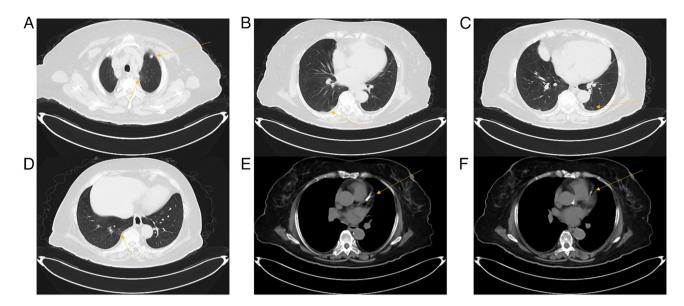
Chest CT demonstrating (A) a large nodular shadow in the upper lobe of the left lung, (B-D) an increased texture with patchy and corded shadows in different parts of both lungs and (E and F) different branches of coronary artery calcification.
